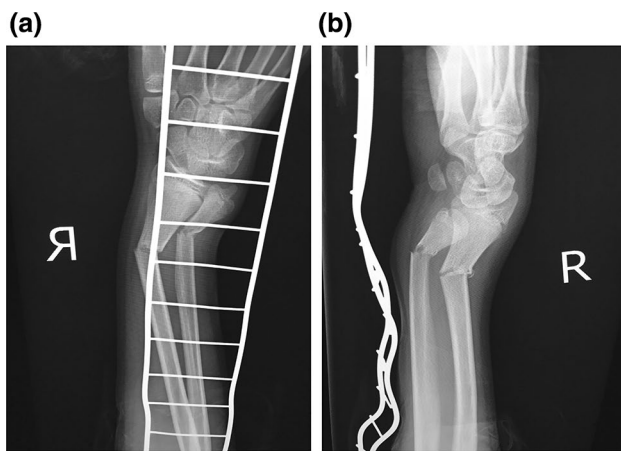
Plain radiography at the time of injury. Fracture of the distal third of both the radius and ulna was noted (a: A-P view, b: lateral view)
